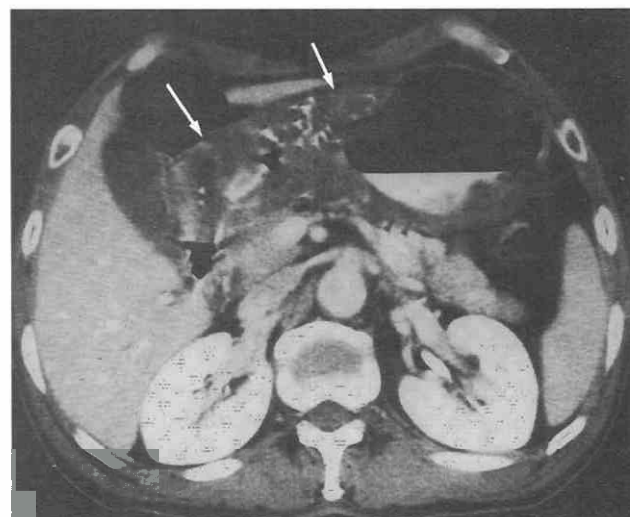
Mucinous adenocarcinoma of the stomach. CT scan shows gastric wall thickening (arrows) with poor contrast enhancement and calcifications.
